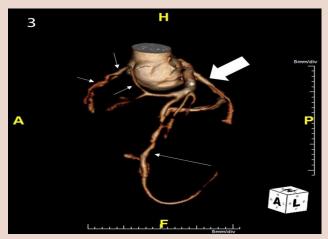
Volume rendered cutaway CT angiogram image of the aortic root and coronary arteries. Note the solitary coronary artery originating from the left coronary sinus giving rise to the left anterior descending (long thin white arrow), left circumflex (thick white arrow) and right coronary (short thin white arrows) arteries. The proximal LAD is ectatic (*). Motion artifact is noted in the mid LAD.
